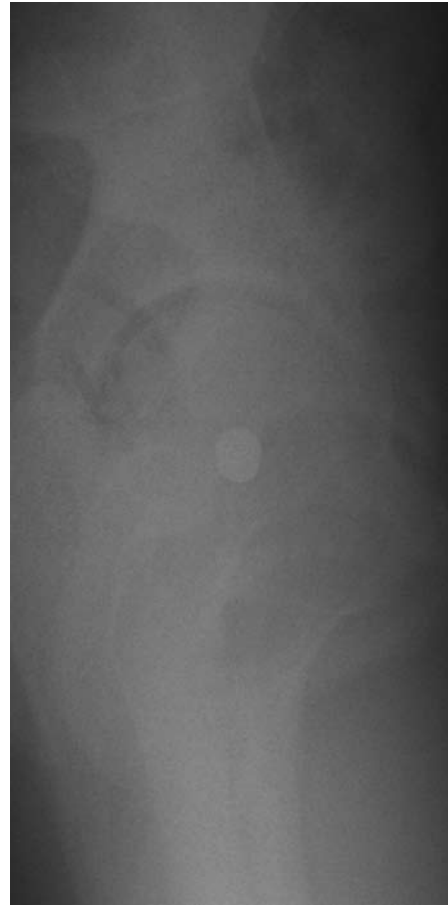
Radiograph of Femor head lateral view..
